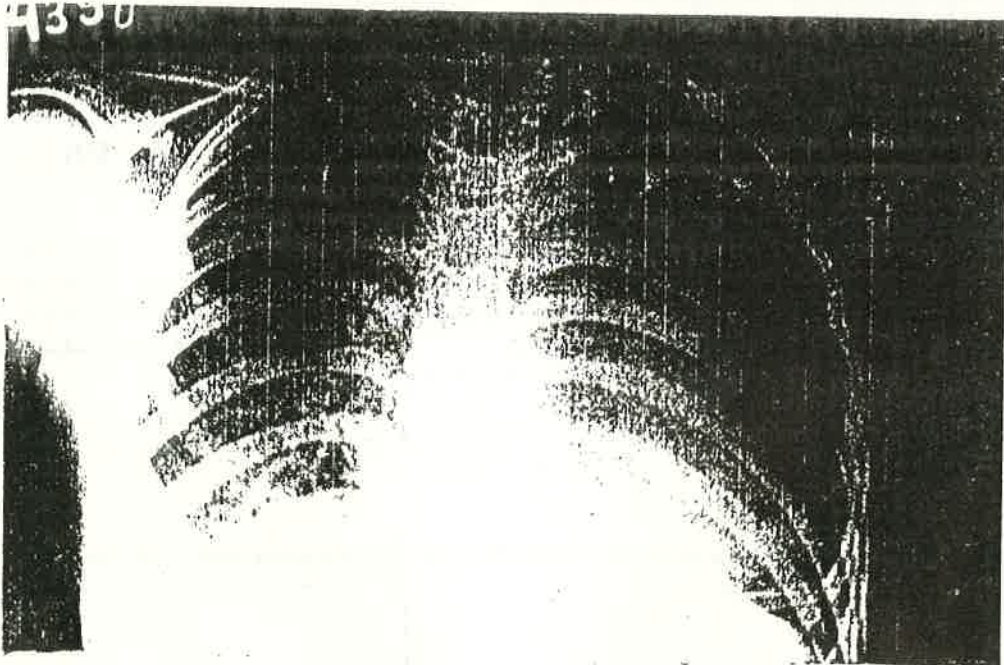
Chest X-ray AP view revealing large cardiac silhouette, taken immediately after permanent thoracocentesis
